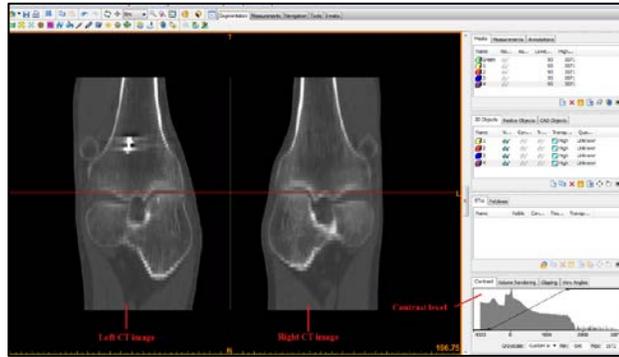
Windowed Knee CT Scan
